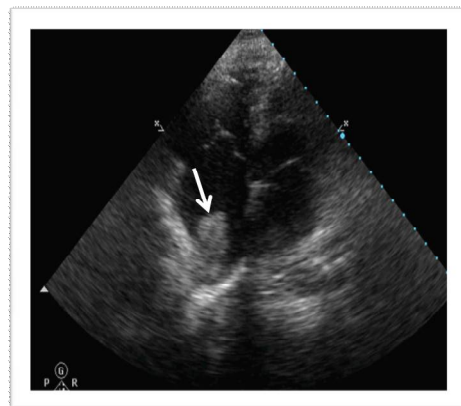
Echocardiography, apical view showing a giant mass in the right atrium (arrow).
